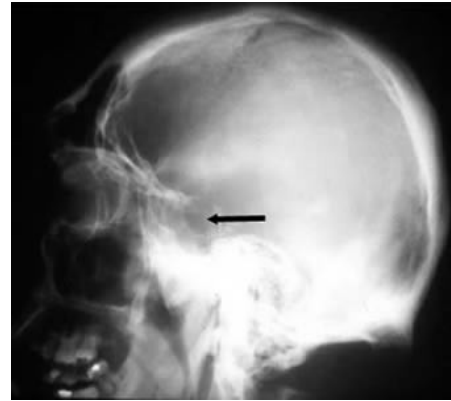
X-ray of sella turcica
